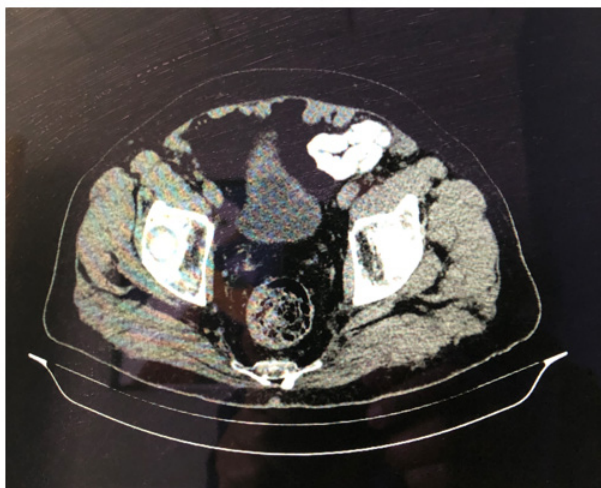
Abdominal CT scan showing the presence of a left inguinal hernia.
